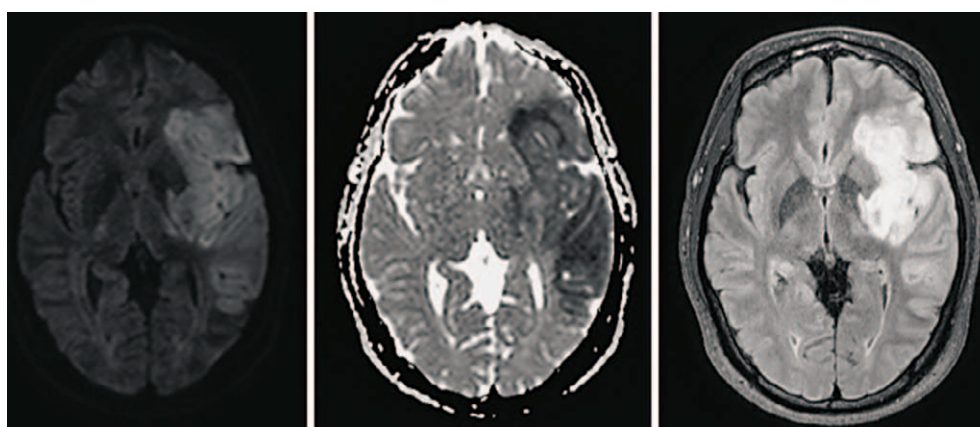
Brain magnetic resonance image (MRI). Evolving infarct involving the area of the middle cerebral artery (MCA)
